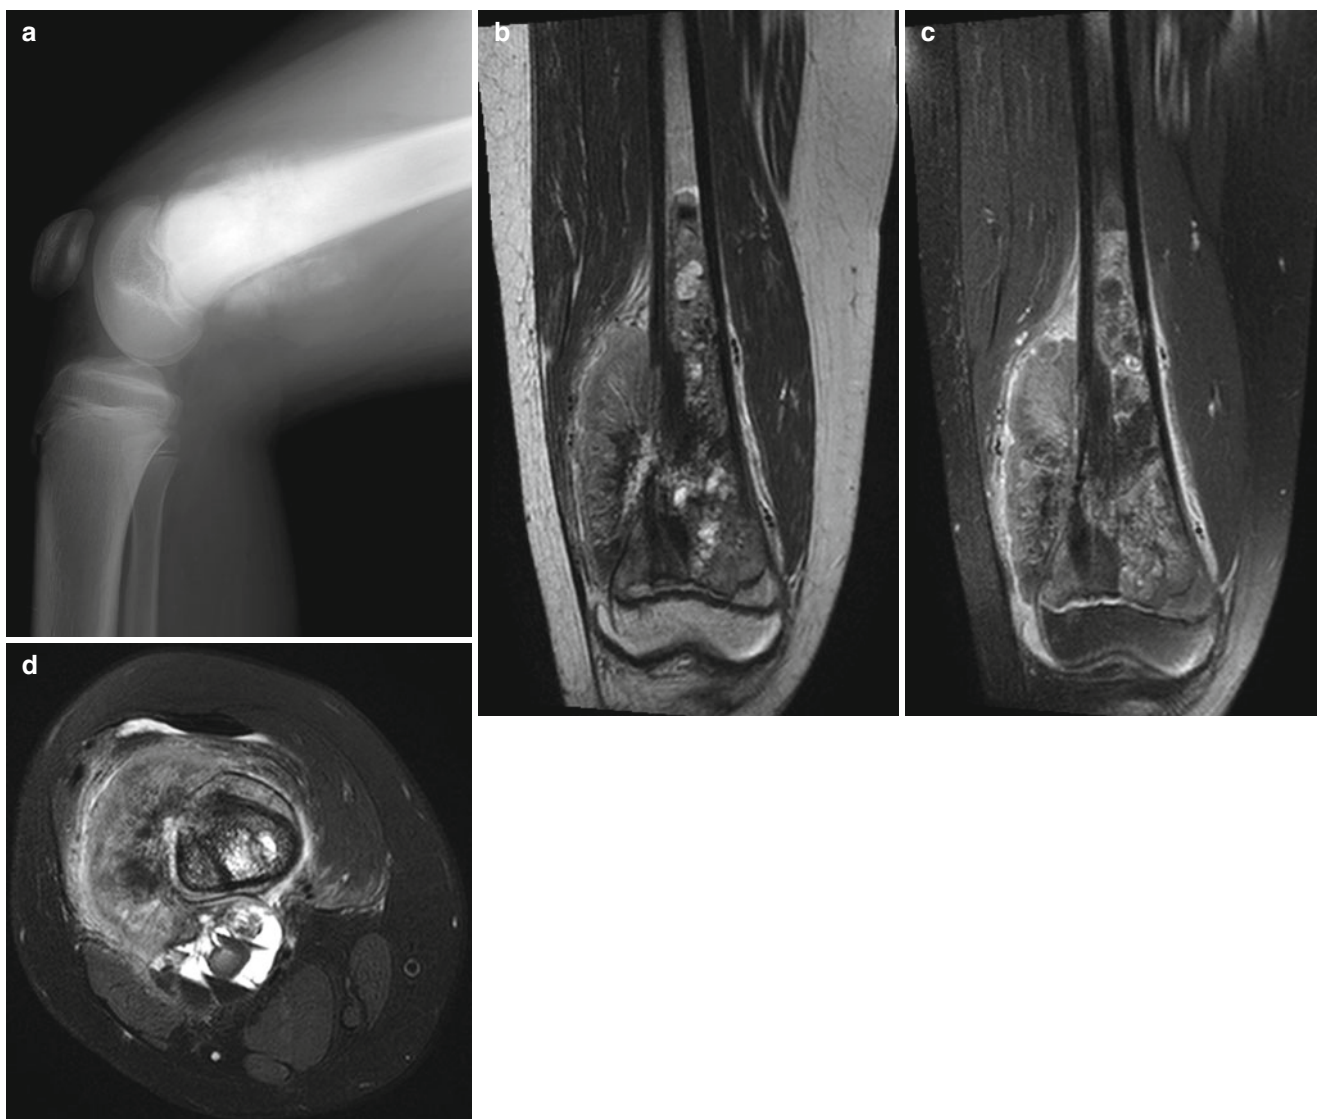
Classic osteosarcoma in a 16-year-old girl.* (a) Ill-defined osteosclerotic bony lesion is seen in the right distal femur metadiaphysis. There is an associated malignant-type periosteal reaction, and the transition between tumor and normal marrow is wide. (b–d) MR T2-weighted coronal (b), postcontrast fat-suppressed T1-weighted coronal (c), and axial T2 SPAIR (d) images show a large heterogeneous
